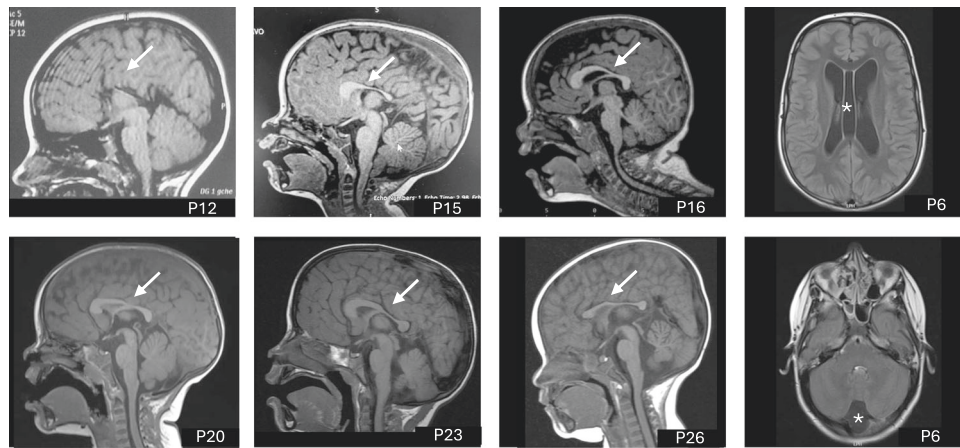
Brain magnetic resonance image (MRI) of individuals with *CNOT3* variants. Note hypoplastic, absent and dysmorphic corpus callosum (white arrows), septum pellucidum cyst and retrocerebellar cysts (white asterisks).
